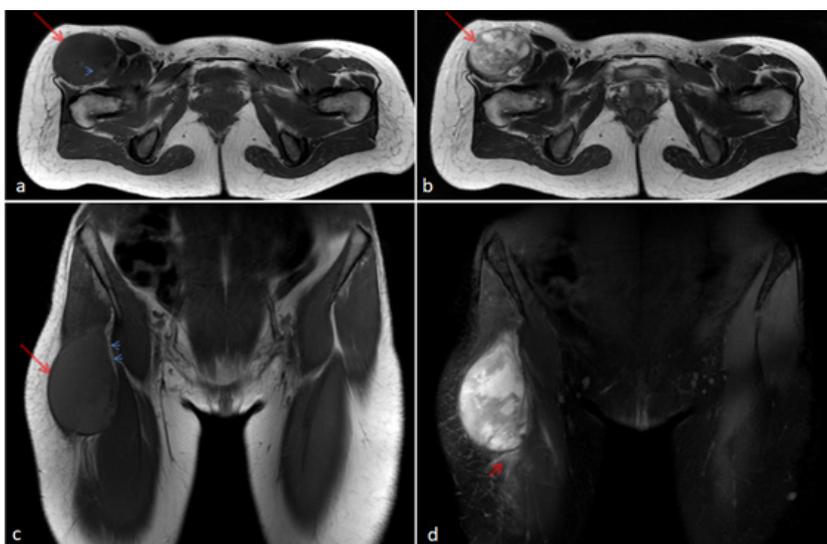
Magnetic Resonance (MR) images of the proximal thighs. Axial T1-weighted-image (a) showing a mass (arrow) with intensity similar to that of muscle. Note also small hyperintense areas (arrowhead), probably reflecting hemorrhagic foci. Axial T2-weighted-image (b) reveals heterogeneous high signal of the mass (arrow). Coronal T1-weighted-image (c) shows that the mass (arrow) has a fusiform shape with well-defined contours and a rim of fat (arrowheads). Coronal T2-SPAIR image (d) reveals small perilesional area (arrow).
